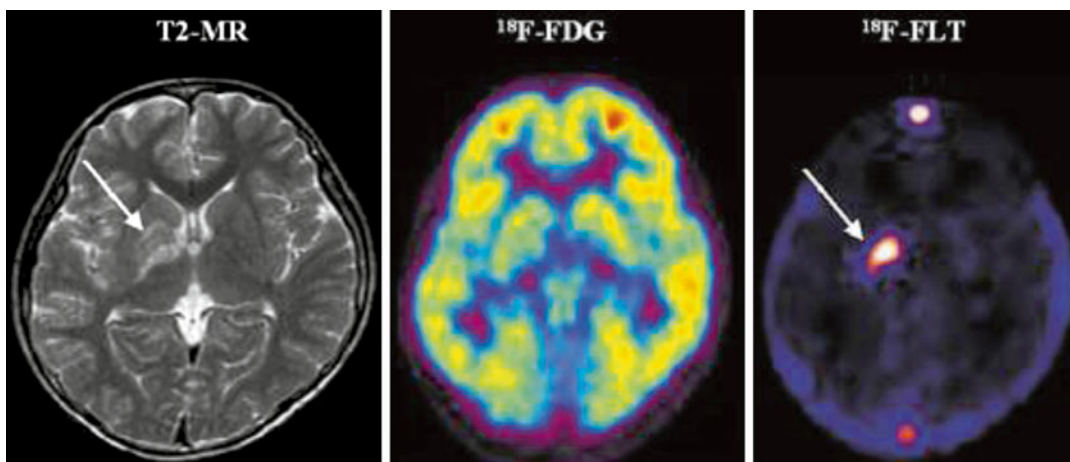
An 11-year-old male with a germ cell tumor of the basal ganglia. MR shows subtle changes (*arrow*) in the right basal ganglia. On [^{18}F]-FDG PET, the right basal ganglia lesion shows slightly decreased uptake compared with the contralateral basal ganglia but increased uptake
